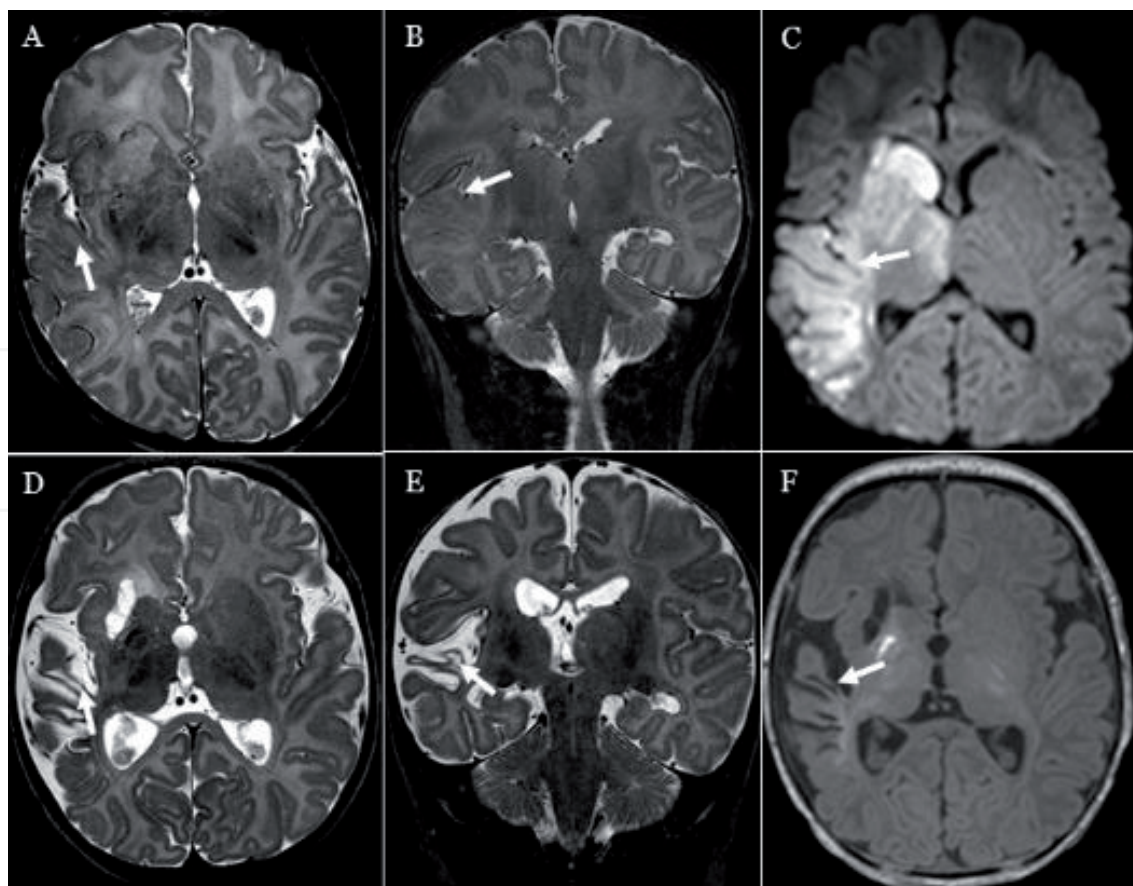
Images showing the evolution of perinatal ischemic injury involving the right temporal lobe and the right basal ganglia. Axial T2w (A), coronal T2w (B) and DWI (C) images of 2 days newborn during the acute phase of the ischemic injury. Axial T2w (D), coronal T2w (E) and axial T1w (F) images showing the massive damage after 42 days; the involvement of the primary auditory cortex (arrows) caused SNHL.
